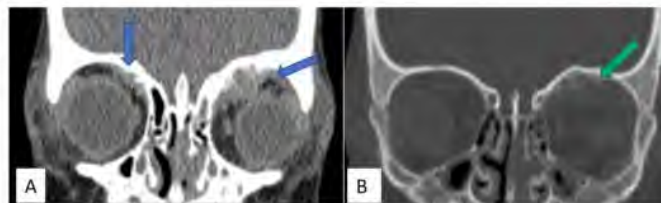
Neuroblastoma Metastasis (A) Coronal CT image (soft tissue window) shows a well-defined hyperdense homogenous masses involving both the orbital roof medially (blue arrows). (D) Coronal CT image (bone window) shows underlying characteristic 'spiculated' periosteal reaction seen with neuroblastoma metastasis involving the left orbital roof (green arrow)
